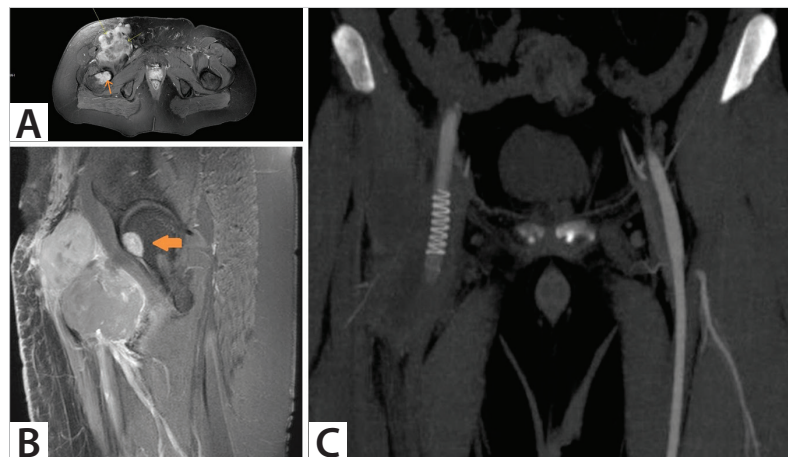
A. In contrast-enhanced MRI scan, in the axial MRI view of T1A sequence post contract fat suppression, common femoral artery (short yellow arrow), the central cystic-necrotic infiltrative mass lesion with dense heterogeneous contrast involvement in the pseudo-aneurysm region (long yellow arrow), metastatic lesion is observed in the medulla-trabecular area with intense contrast enhancement (orange arrow). B. In contrast-enhanced MRI scan, in the sagittal MRI view of T1A sequence post contract fat suppression, infiltrative, heterogeneous contrasting mass lesion and femoral head metastatic lesion (orange arrow). C. In the arterial phase extremity CT angiography, after endovascular stent graft inserted in the common femoral artery, the stent lumen open and the pseudo-aneurysm sac with thrombosis.
